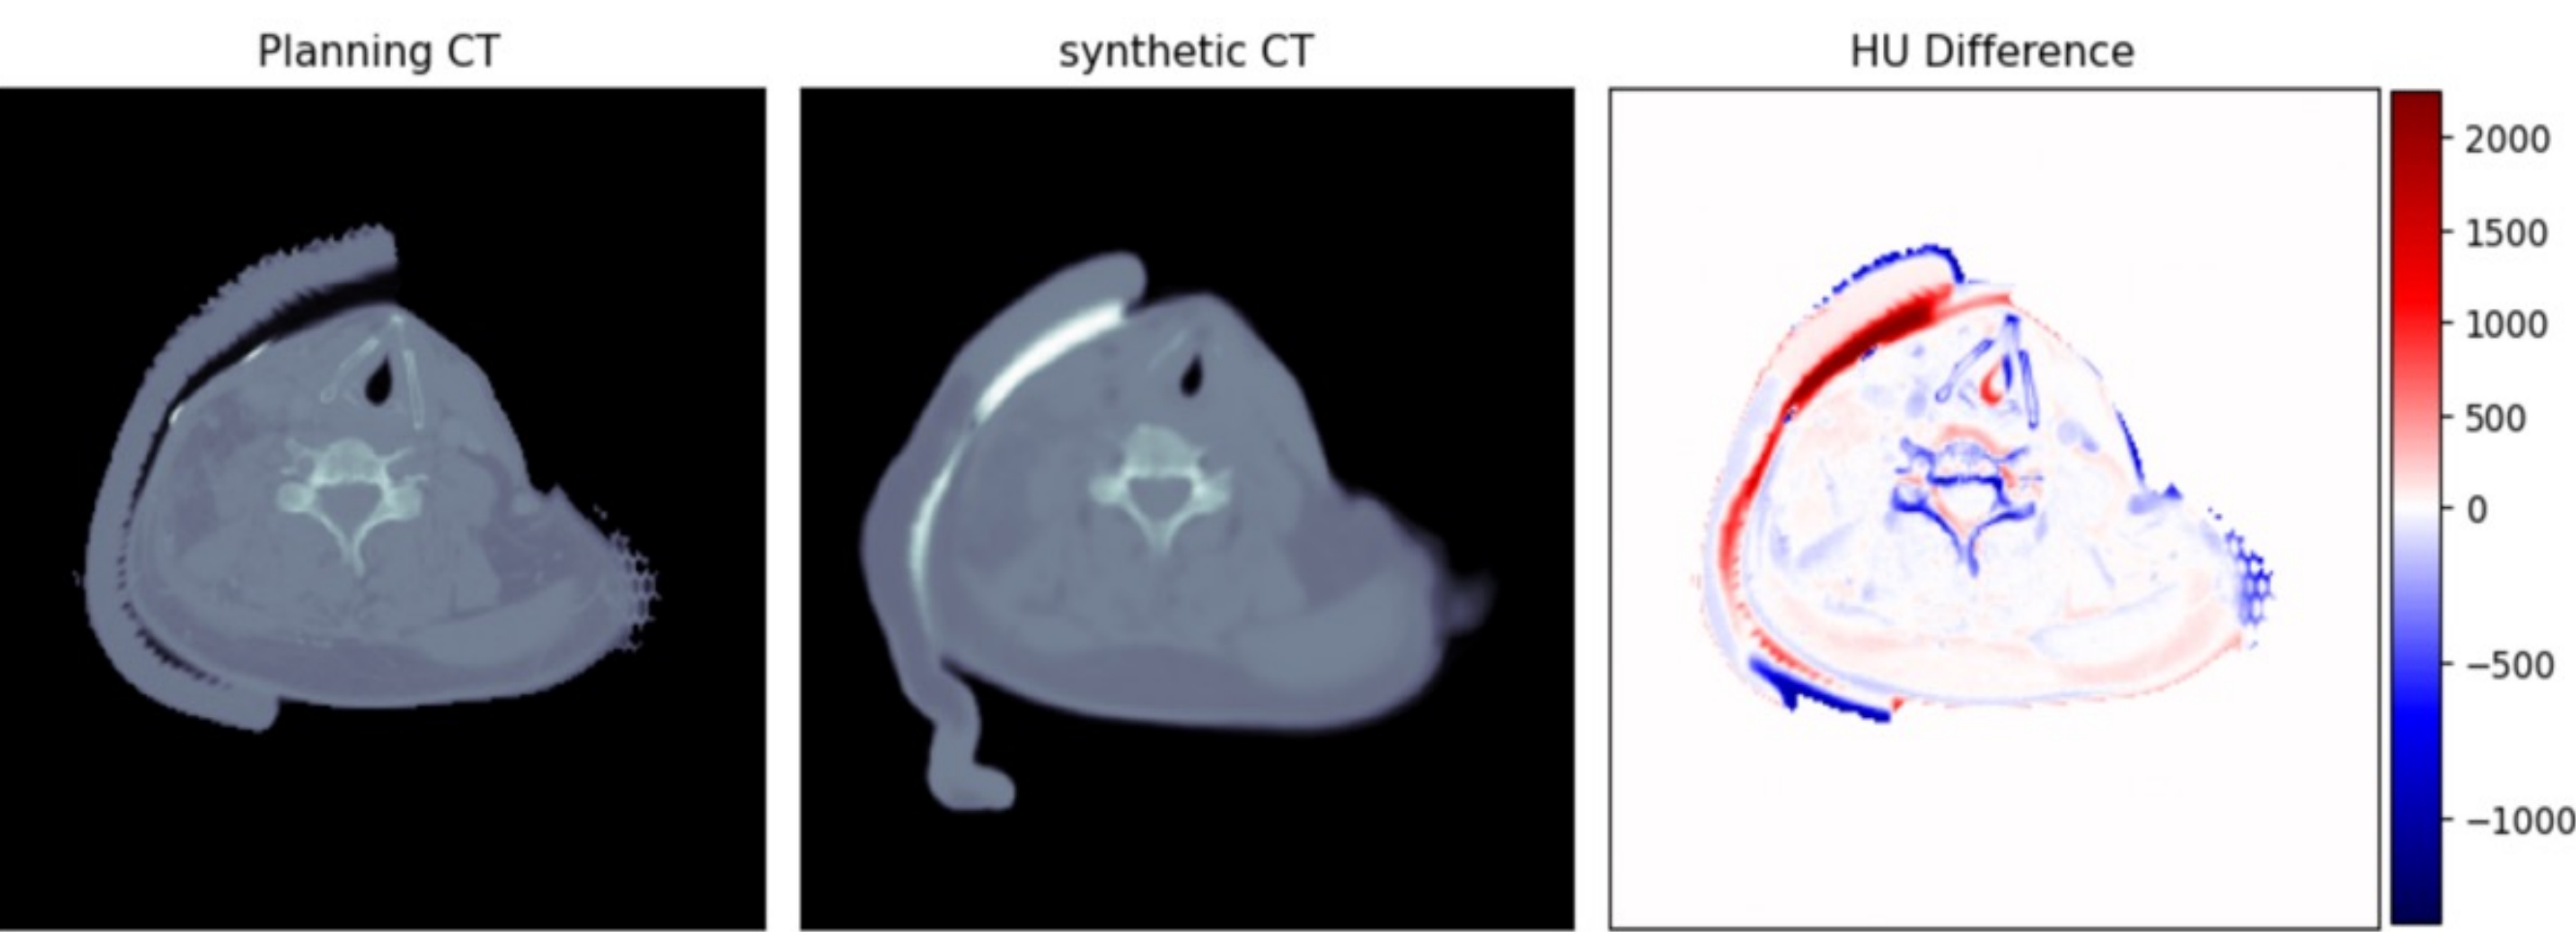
Difference map computed within the intersection of the pCT and sCT body contours. The difference map shows the evaluation mask used for calculating the MAE. Left: planning CT (pCT). Middle: synthetic CT (sCT). Right: difference map (sCT – pCT). The diverging colormap is zero-centered (white = 0 HU), with red indicating positive HU error (sCT > pCT) and blue indicating negative HU error (sCT < pCT).
